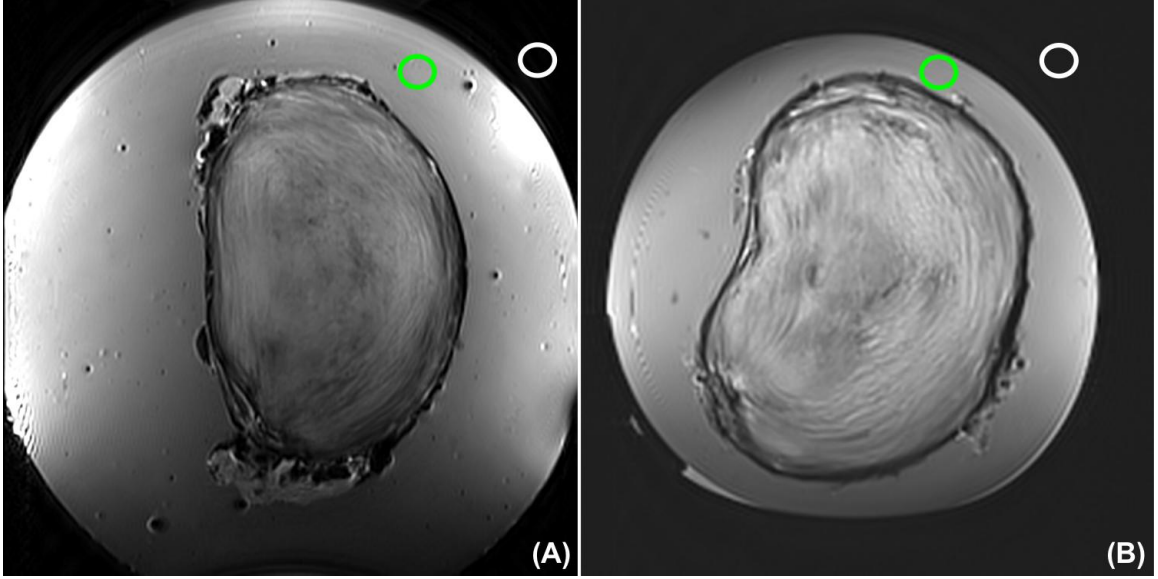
Representative mid-axial MR images with (A) and without (B) loading frame. Signal to noise ratio (SNR) was measured using a region selected within the agarose (Green) to represent signal, as these samples come from different lumbar levels (Noise – White).
